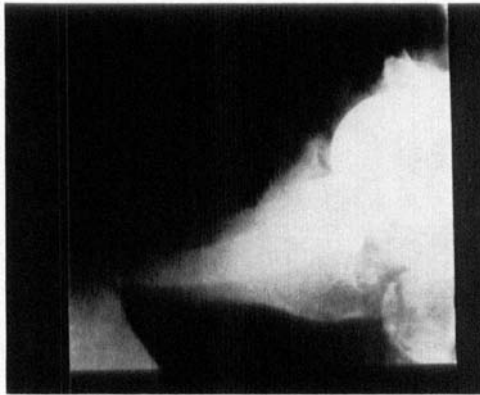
Collateral radiograph.
